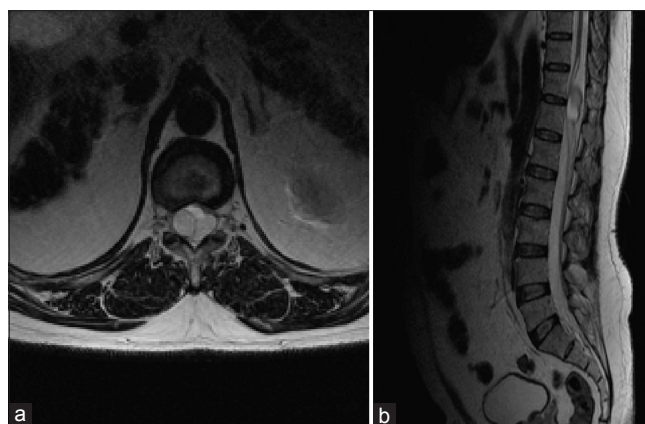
Magnetic resonance imaging. (a) Axial and (b) Sagittal T2 images show a heterogeneous cystic lesion at the level of the conus. The lesion appears intradural extramedullary
